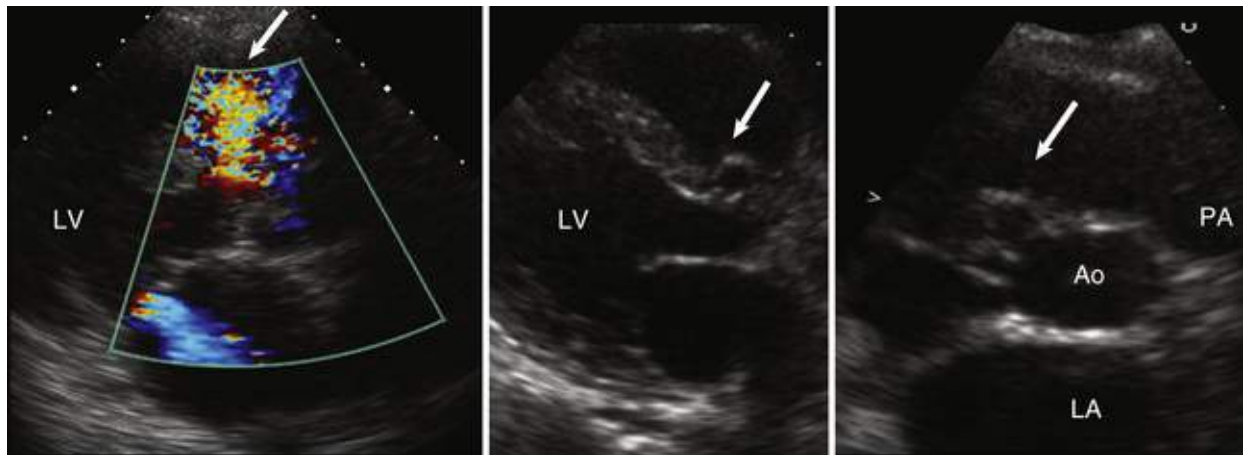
Parasternal views of a membranous VSD partially closed with a wind-sock aneurysm. Left, A systolic left-to-right jet is identified. Middle, With slight angulation, a wind-sock aneurysm representing partial spontaneous closure of the defect is identified. *LV*, Left ventricle. Right, In the short-axis view, the wind sock helps localize the VSD to the 11 o'clock position, as opposed to outlet defects, which are seen in the 12 to 2 o'clock position (compare with Fig. 14.93). *Ao*, Aorta; *LA*, left atrium; *PA*, pulmonary artery.
